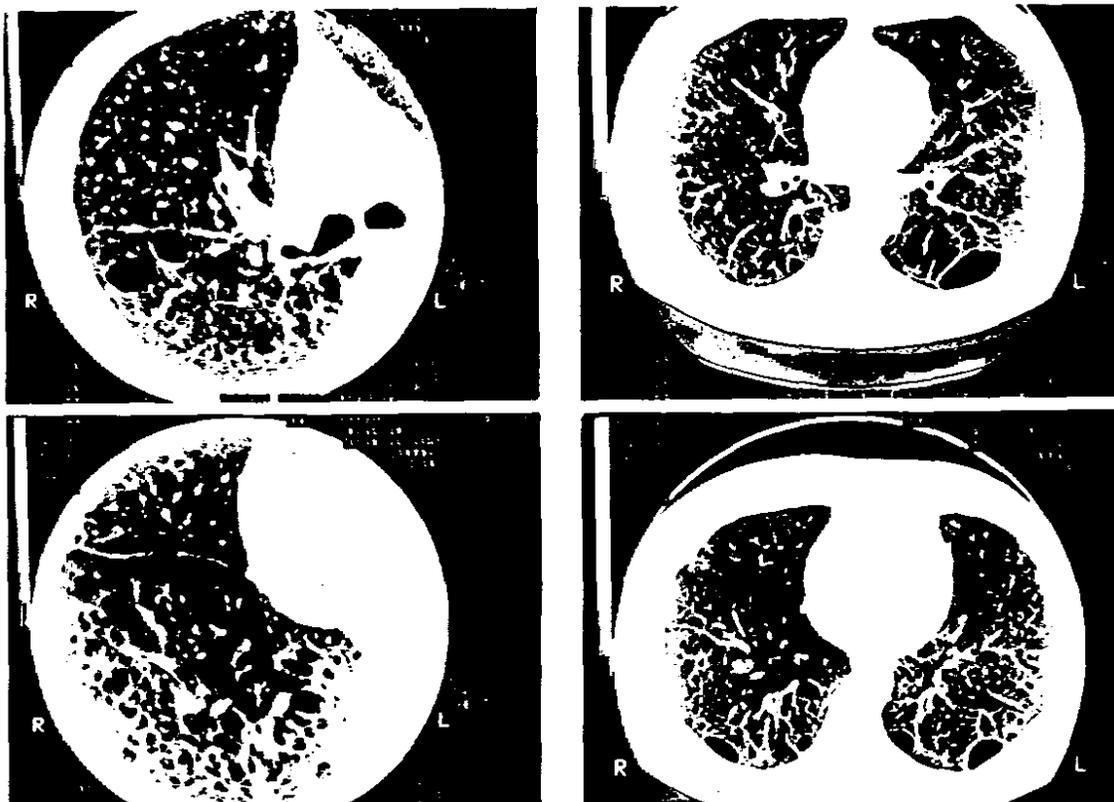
CT images evidently demonstrate strand or streak like interstitial fibrosis, pulmonary emphysema and bullae. On the left super resolution mode images taken by 1.0 mm slice thickness clearly demonstrate impaired lung parenchyma and pulmonary vessels caused by emphysema. The presence of large bullae of the left lung posterior region shows hyperlucency on the chest radiograph.
